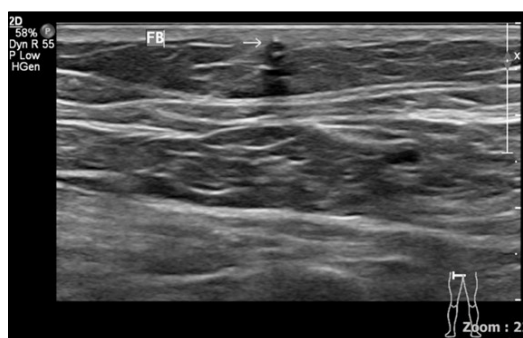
Targeted ultrasound over the right femoral region reveals a tubular-walled structure (white arrow) in the superficial subcutaneous tissue in the right femoral region, located parallel to the femoral vein below.
